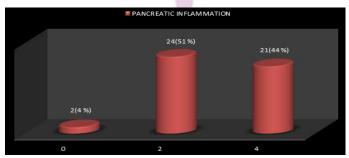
Number and percentage of patients with scoring based on pancreatic changes in CT
